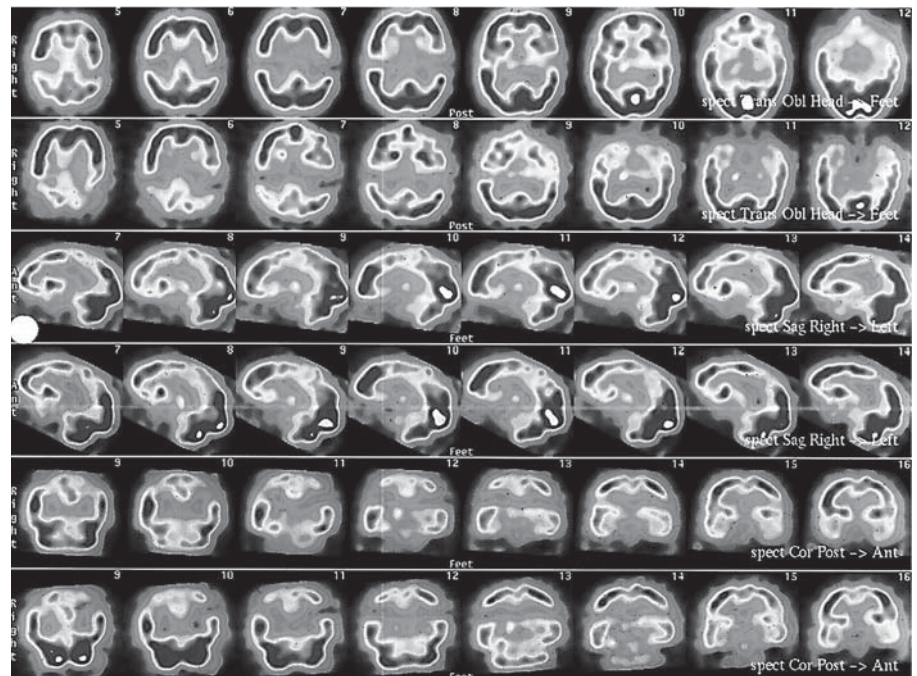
⁹⁹Tc-HMPAO SPECT showing reduced captation of the tracer in both parietal regions (taken from Puertas et al. [18], with permission of Viguera Editores, *Revista de Neurología*).
